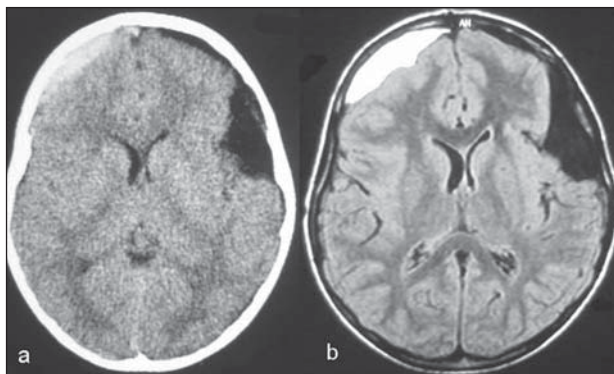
(A) CT scan and (B) MRI showing left temporal arachnoid cyst with subdural hygroma adjacent to the cyst associated to an acute subdural hematoma contralateral to the cyst.
